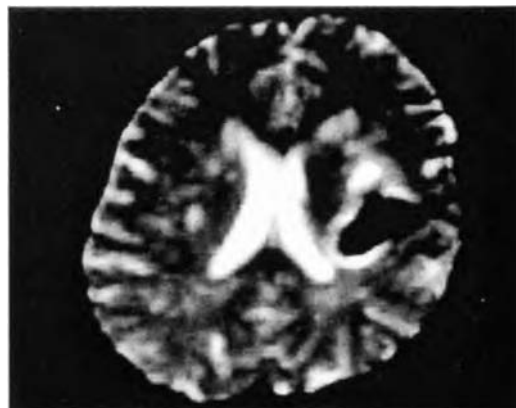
T2 weighted MRI shows left putamen with mild adjacent oedema and mass effect.
